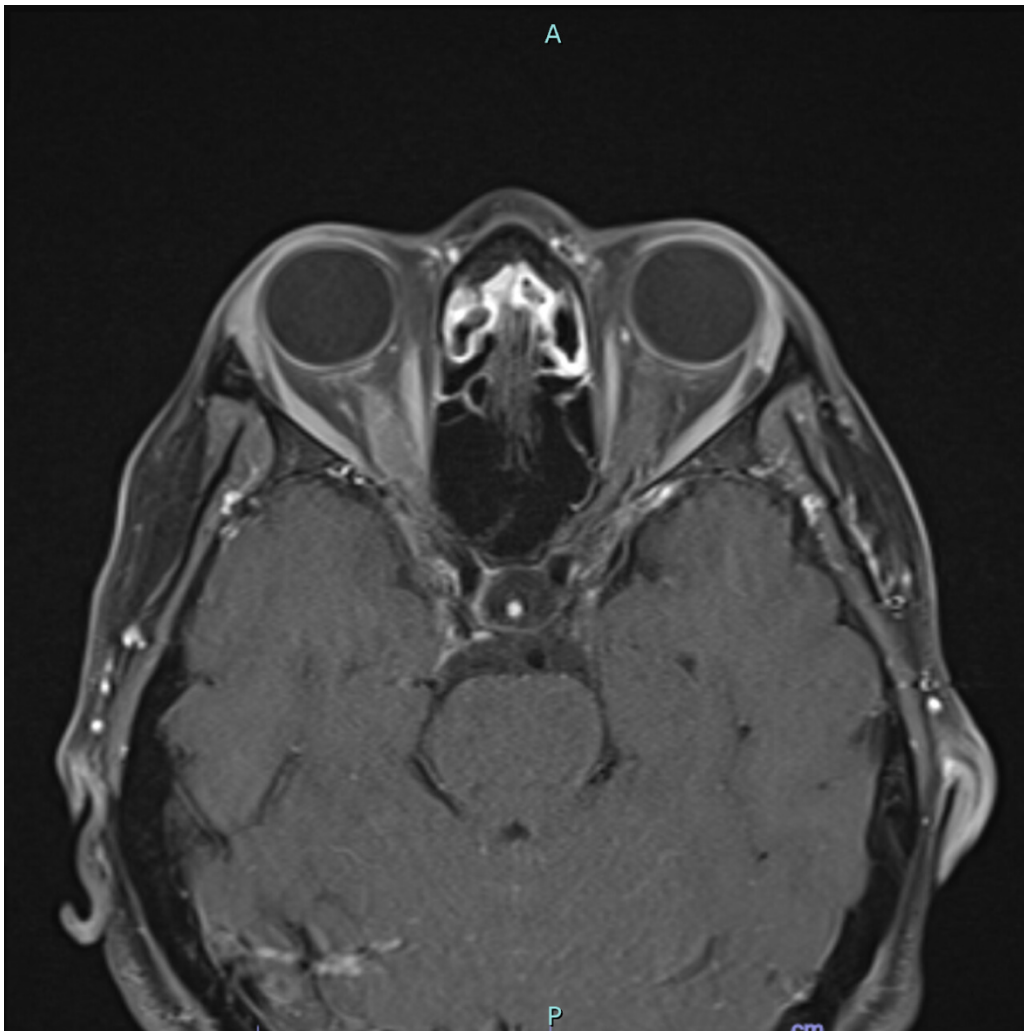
Axial magnetic resonance images demonstrating asymmetric, irregular enhancement and enlargement of right optic nerve in the retrobulbar region.
